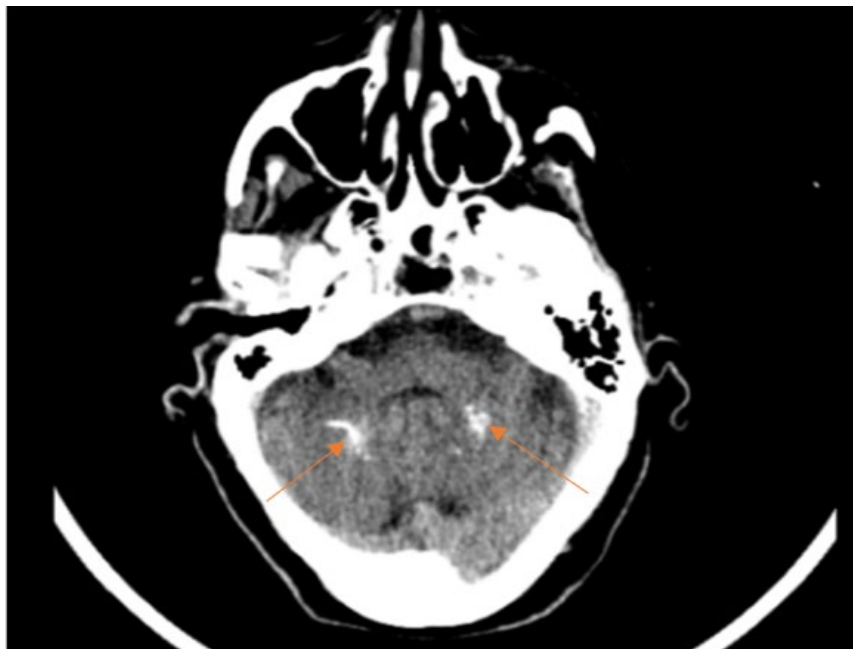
Image from brain CT scan, with calcified lesions in the dentate nuclei of the cerebellum.
